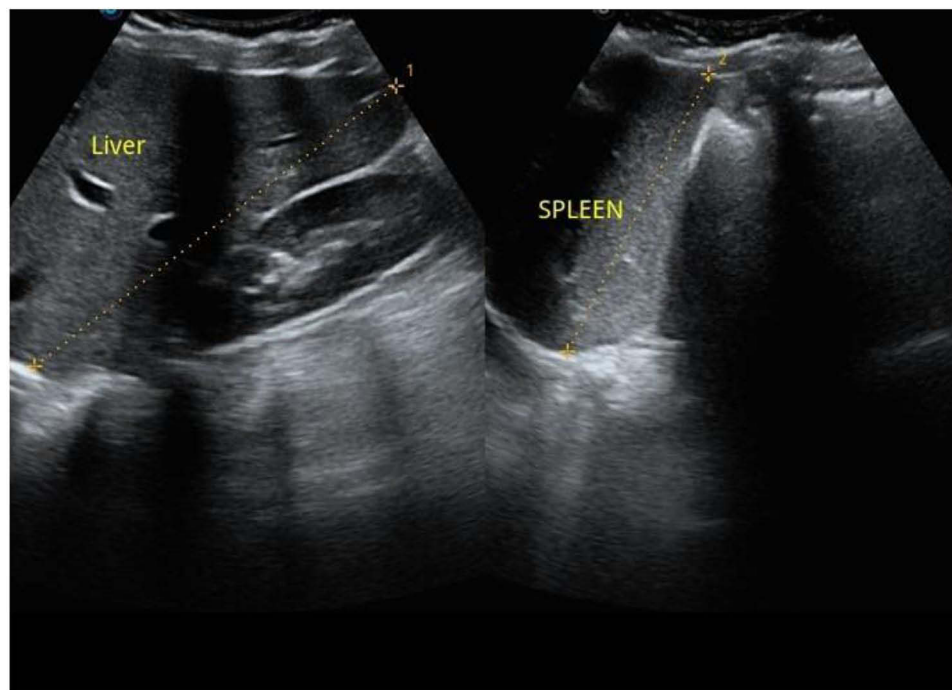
Follow-up normal abdominal ultrasound.
